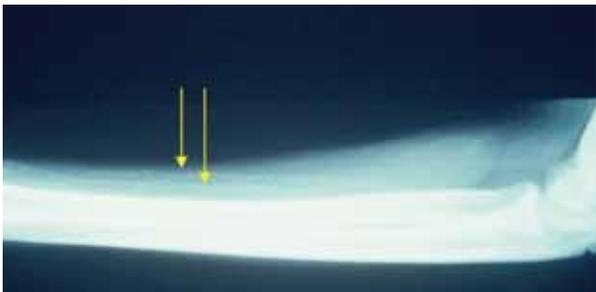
X-ray of the forearm in a 16-year-old patient (note epiphysis not fused) showing extensive medial calcification due to elevated calcium x phosphorus product.
